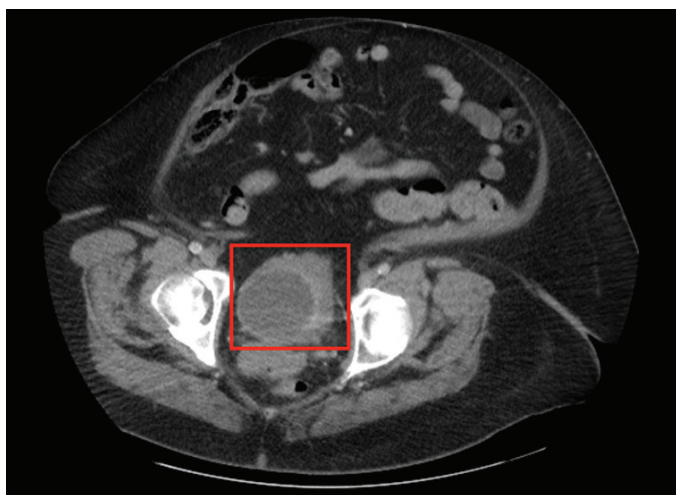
CT abdomen and pelvis imaging revealing granulomatous cystitis. Persistent soft tissue thickening and infiltration of the bladder anteriorly and along the left lateral wall with a mass-like component of this thickening measuring 3.8x2.6 cm along the anterior bladder floor
